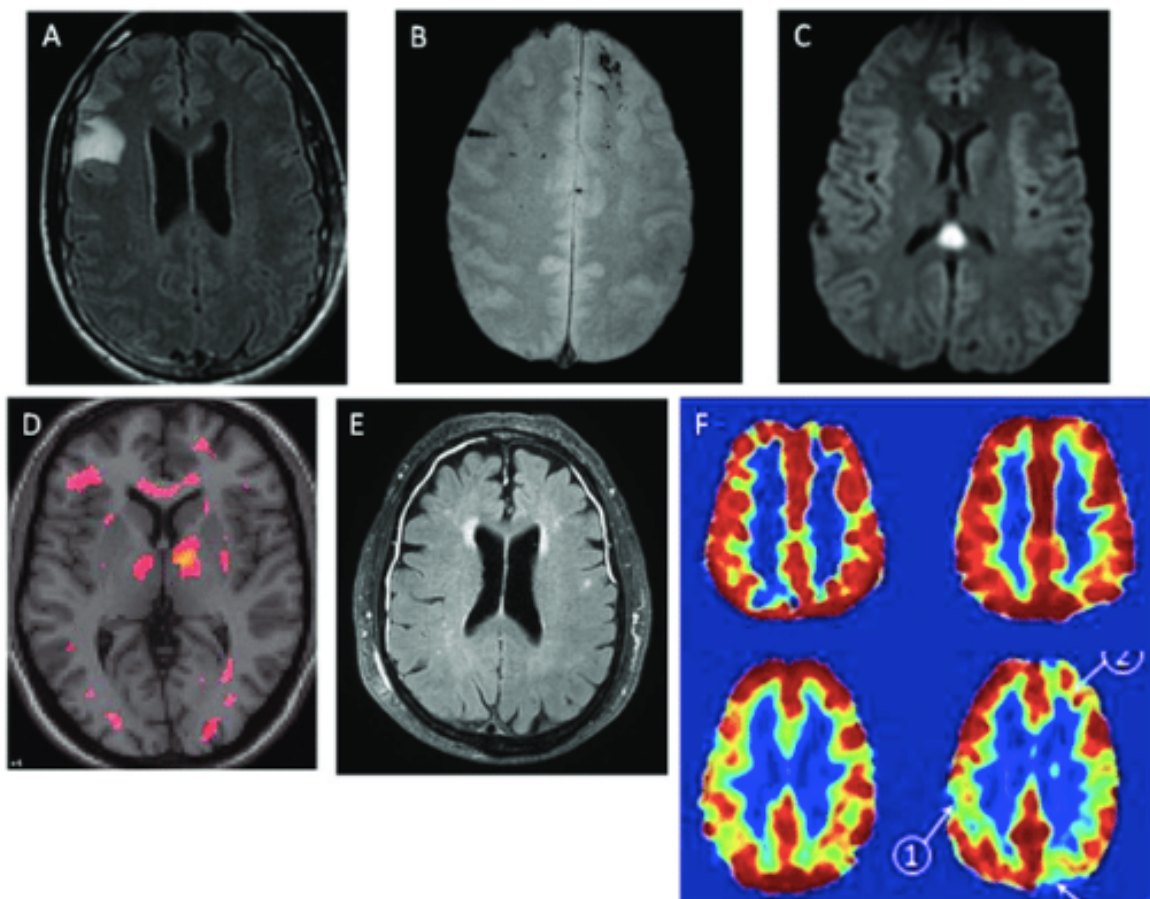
MRI of post-concussive symptoms after mTBI. In each case, cranial CT was normal and MRI was obtained within 48 h on injury. (A) Right frontal non-hemorrhagic contusion, on FLAIR. (B) Linear microhemorrhages in left and right frontal lobes, on T2*
